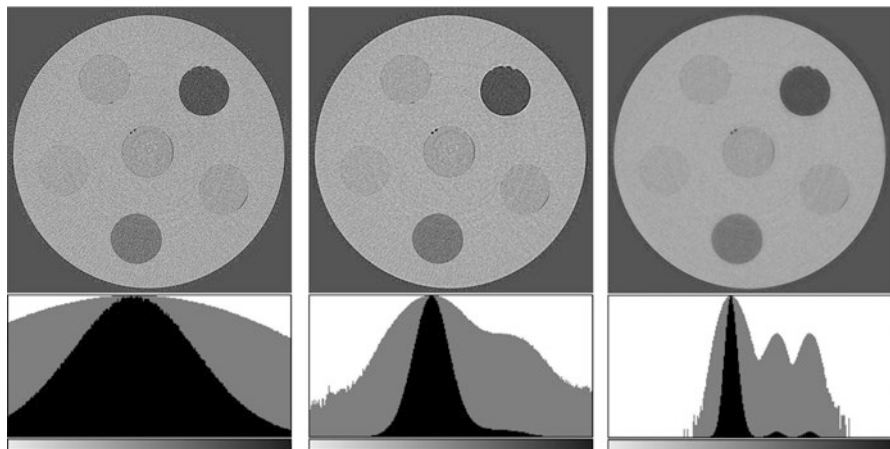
A comparison of different reconstructions when considering a CT dataset with a reduced number of projections. From left to right: conventional analytic method (FBP); a hybrid approach (MR-FBP); algebraic method (SIRT). The corresponding gray-level histogram is reported below each image (the same gray-level window was used for all the images) [Linear scale gray-level histogram in black and logarithmic scale in gray]
